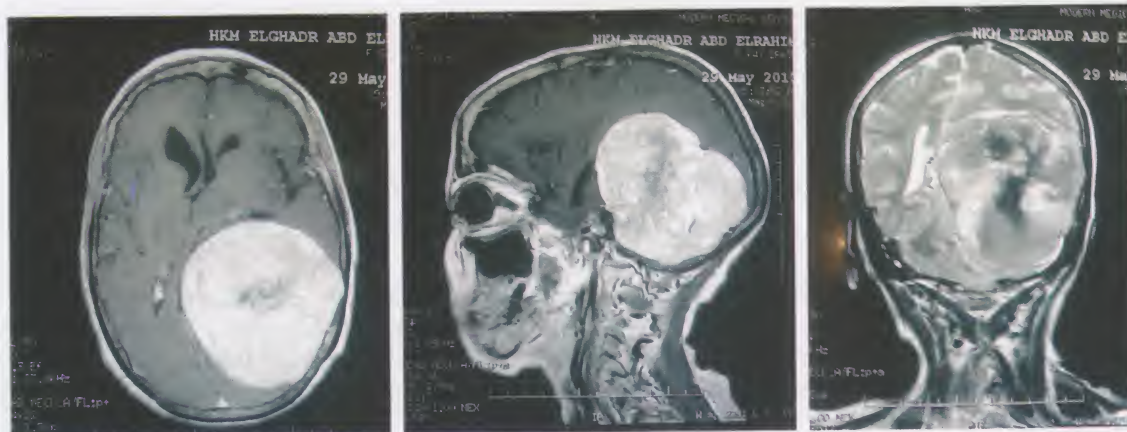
MRI axial and sagittal (post-contrast T1 weighted images) and coronal (T2 weighted image) of the brain (from left to right) showing a patient with a large cerebral tumor
